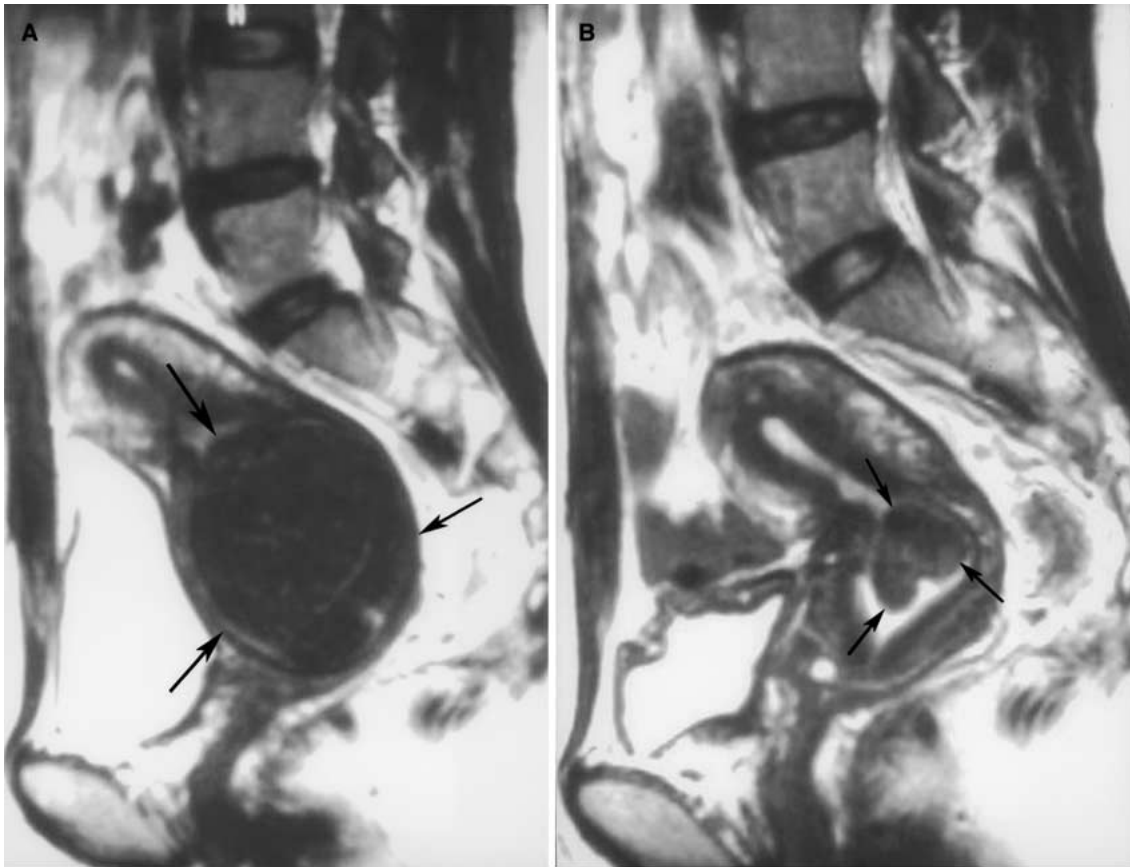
Patient no. 1 was a 29-year-old woman with submucosal myoma. (A) T2-weighted sagittal MR image shows an 8 cm submucosal myoma (arrows). (B) At follow-up MRI 3 months later after UFE, a small residual myoma
